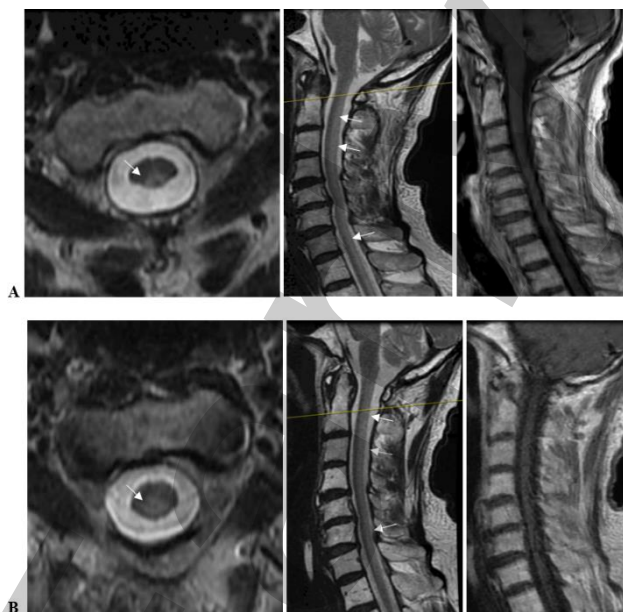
A) Cervical spinal magnetic resonance imaging (MRI) at initial presentation (first month of complaint onset), axial T2, sagittal T2, and sagittal contrast-enhanced (C+) T1, respectively. arrows; T2 hyperintense longitudinally extensive transverse myelitis (LETM); B) Spinal MRI repeat at 8th month, axial T2, sagittal T2, and sagittal C+ T1, respectively. arrows; LETM without change
